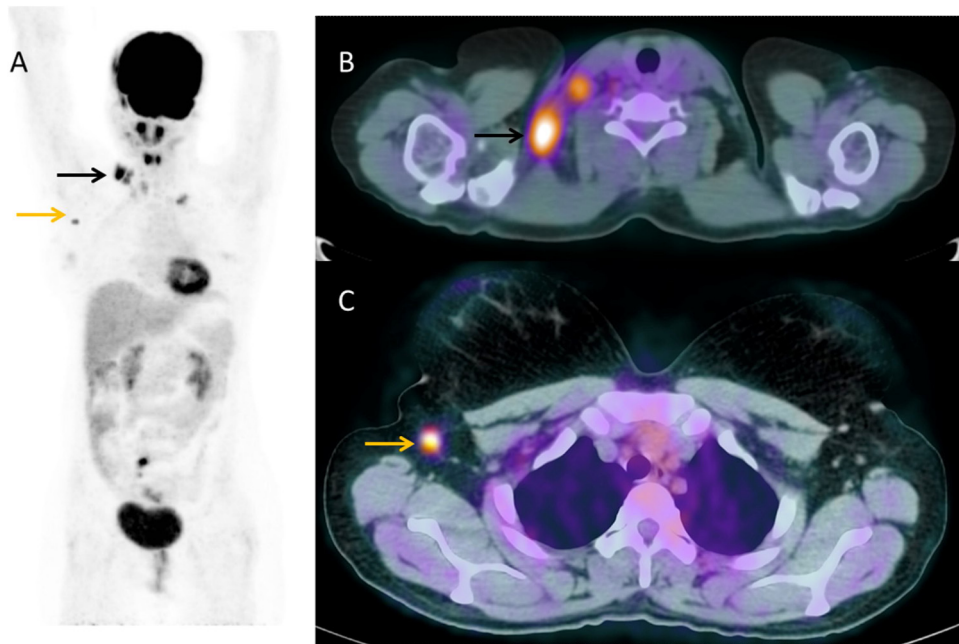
^{18}F -FDG PET/CT scan showing nodal extrapulmonary tuberculosis in a 35-year-old female patient. (A) Whole-body projection is shown. The black arrow indicates F-DG uptake in the right supraclavicular lymph nodes, which were palpable on clinical examination. The yellow arrow shows additional F-DG uptake in a small right axillary lymph node that was not palpable. (B) Transaxial fused images at the level of the supraclavicular region showing the palpable lymphadenopathy (black arrow). (C) Transaxial fused images at the level of the axillae showing an additional site of disease in a small right axillary node (yellow arrow).
